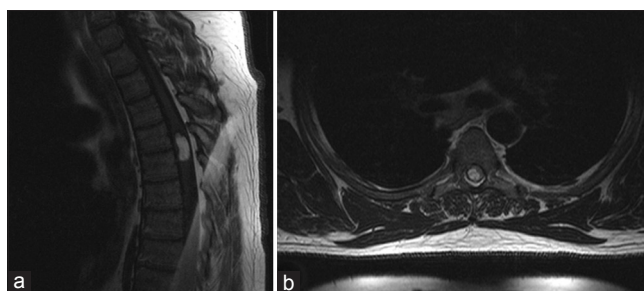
Preoperative T1-weighted magnetic resonance images showing T4/5 intramedullary spinal cord lipoma in the sagittal (a) and transverse planes (b)
